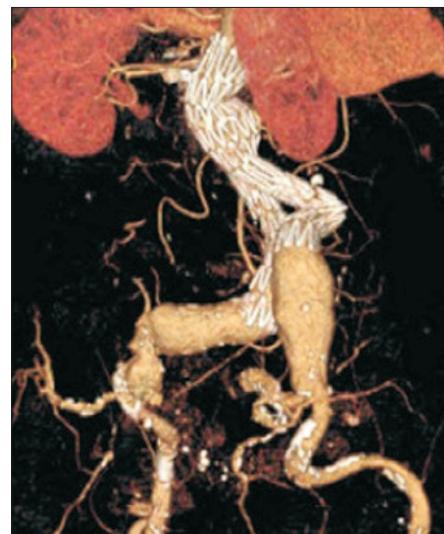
The angio-computed tomography image obtained in 2014 showing the kinked left limb stent graft. The aneurysm sac located at the infrarenal area is around 7.2 cm. The common iliac artery is dilated up to 41 mm. No definite sign of endoleak is seen at this level.
